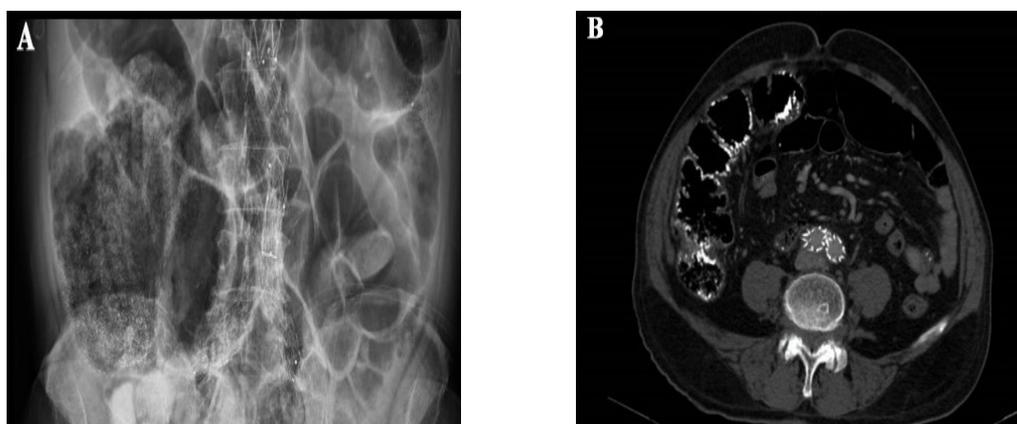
Plain abdominal radiograph (A) and computed tomography (CT) scan (B) of a 64-year-old male patient with a blood lead level of 89 μ g/dL. Several tiny metallic densities can be seen in the colon and ileal loops.
